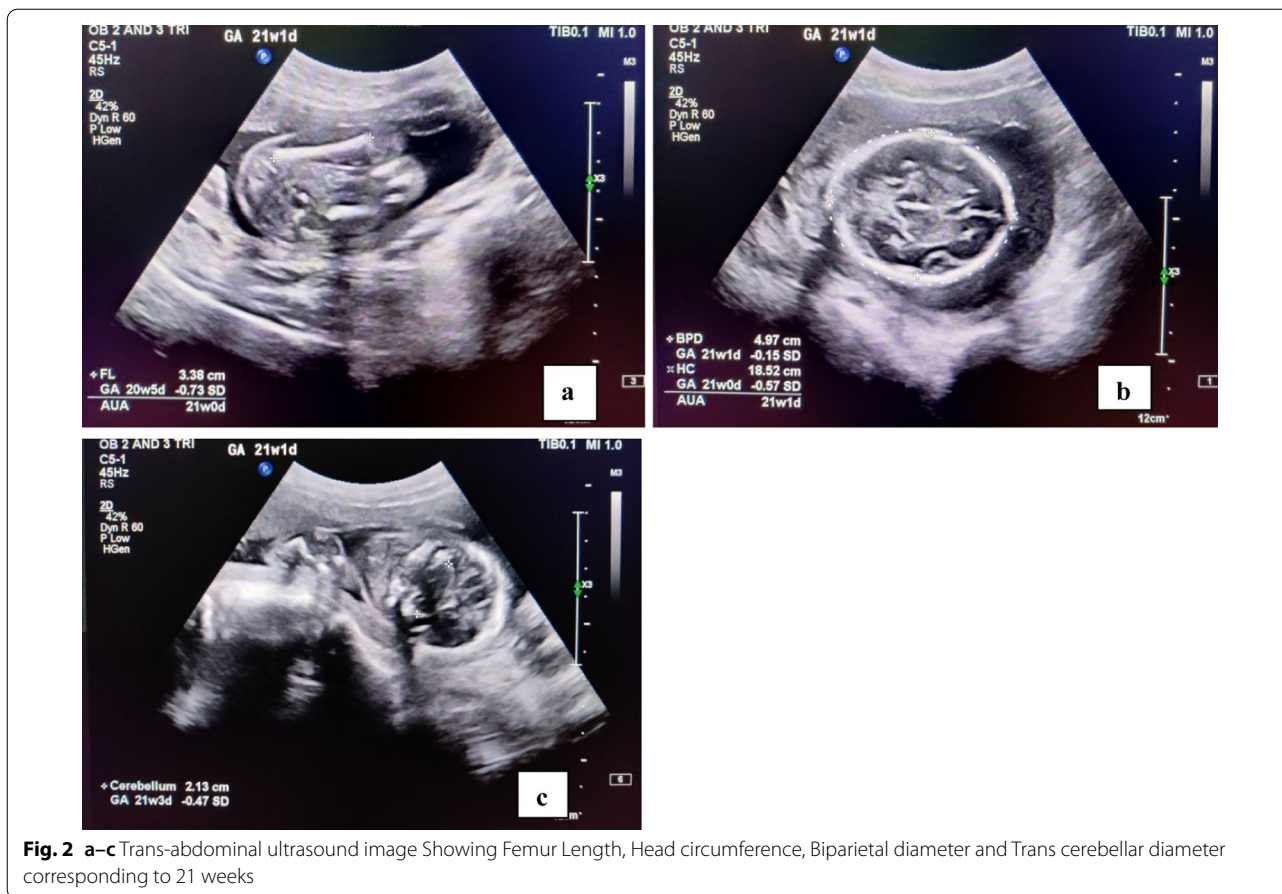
a–c Trans-abdominal ultrasound image Showing Femur Length, Head circumference, Biparietal diameter and Trans cerebellar diameter corresponding to 21 weeks
